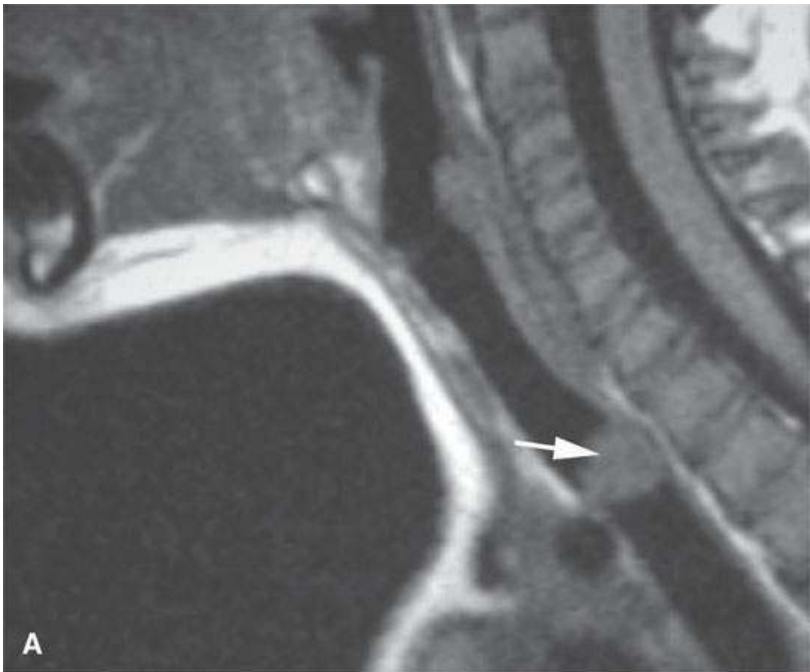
Magnetic resonance imaging in a pediatric patient with mucoepidermoid carcinoma of the trachea. A: Non-contrast-enhanced T1-weighted (T1W) image. B: Contrast-enhanced T1W image shows invasion of the trachea (arrows) compared to the remaining normal trachea.
